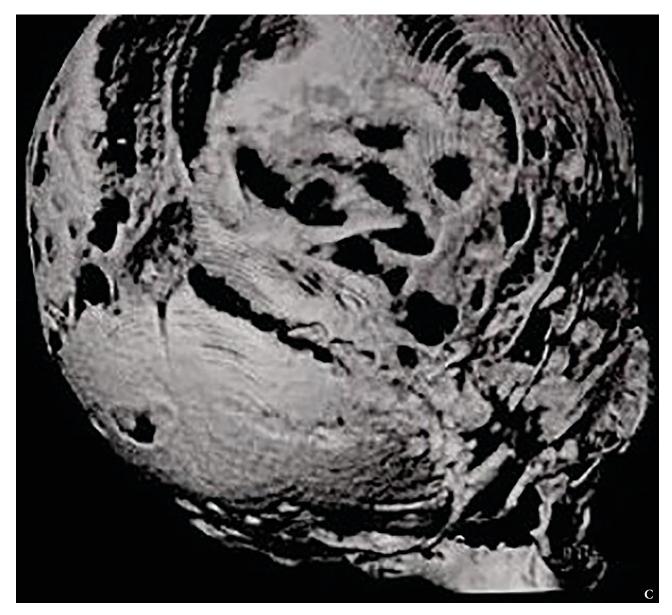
(cont'd). 3D reconstruction CT scans of the skull: left posterolateral view (C). The increase of the space of metopic suture (asterisk) is noted. (Fig 2 continued on next page.)
